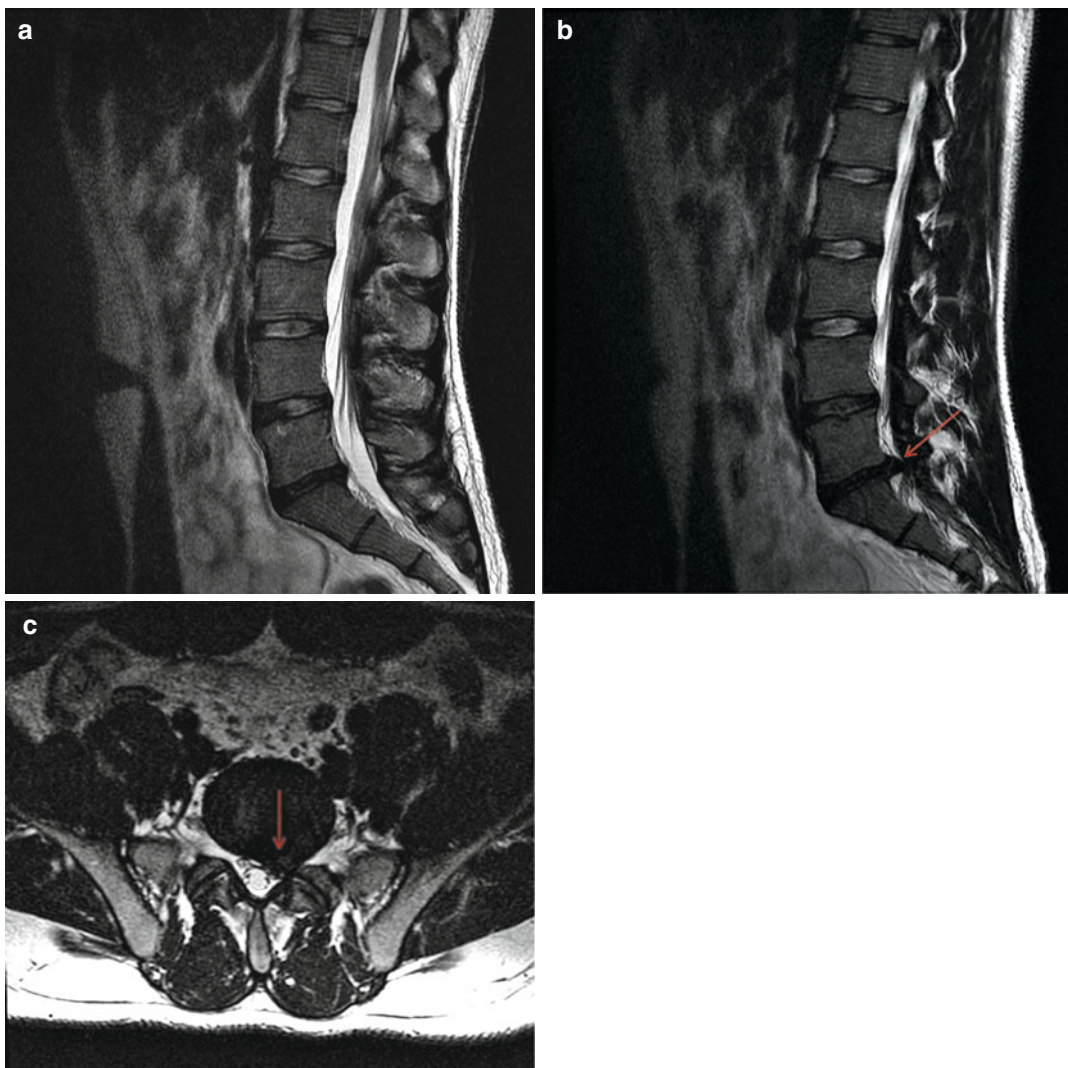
(a) Midsagittal T2-weighted MRI scan of a 26-year-old male presenting with left S1 radiculopathy recalcitrant to nonoperative care. Note that there is no nerve compression apparent on this cut. (b, c) Left-sagittal T2-weighted MRI and axial T2-weighted MRI portraying
